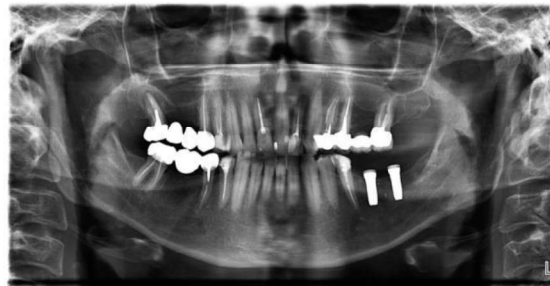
panoramic x-ray after surgery
